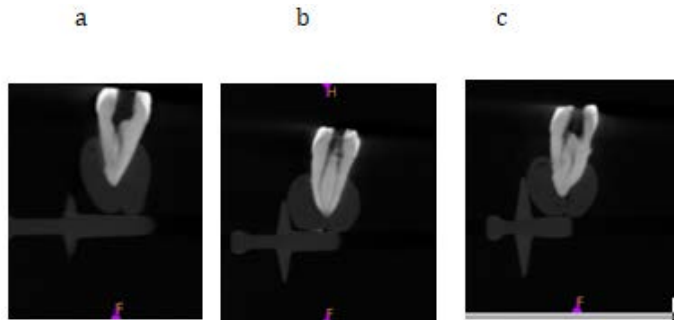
CBCT images of mandibular molar after instrumentation
